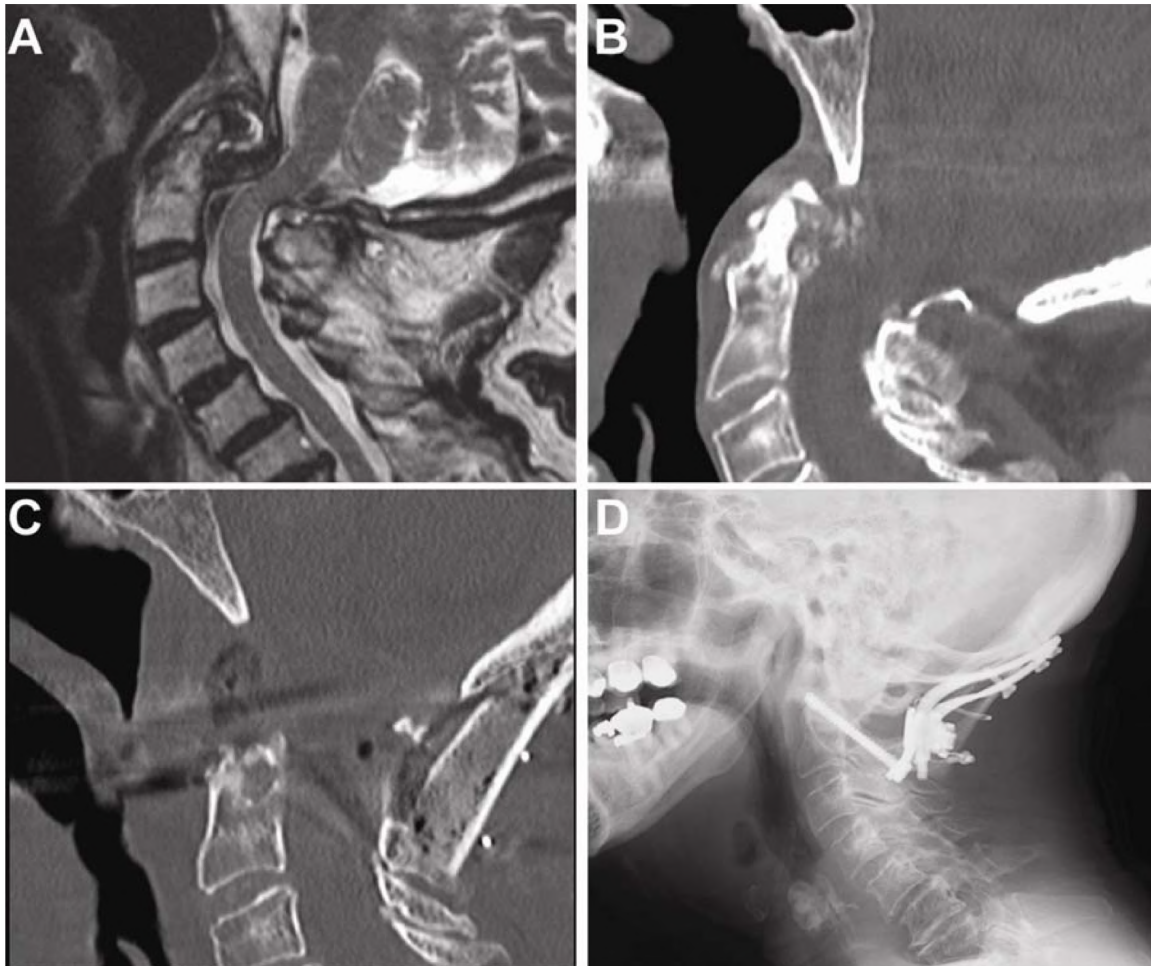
A, Preoperative T2-weighted sagittal MRI; B, preoperative sagittal CT. Both demonstrate severe ventral compression of the craniovertebral junction and posterior deviation of the spinal cord from a large degenerative pannus behind the odontoid process in a 81-year-old woman who presented with neck pain and early myelopathy. A transoral approach was performed to remove the large pannus at the craniovertebral junction followed by a posterior occipitocervical stabilization. C, Postoperative sagittal CT shows resection of the C1 arch, odontoid process, and pannus resulting in excellent decompression of the craniovertebral junction. D, Postoperative lateral cervical spine radiograph showing occipitocervical stabilization construct at 6 months after surgery.
